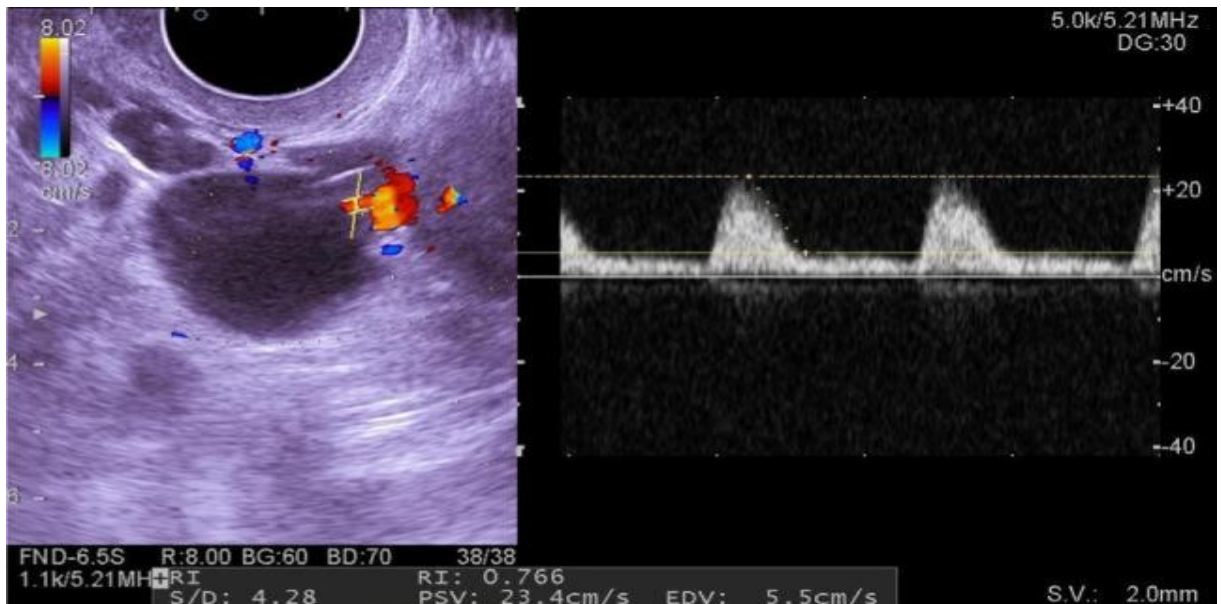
Transvaginal color Doppler ultrasound demonstrating ovarian stromal vascularity with corresponding spectral Doppler waveform analysis. Increased stromal blood flow and reduced vascular resistance are characteristic Doppler findings associated with polycystic ovary syndrome (PCOS).
